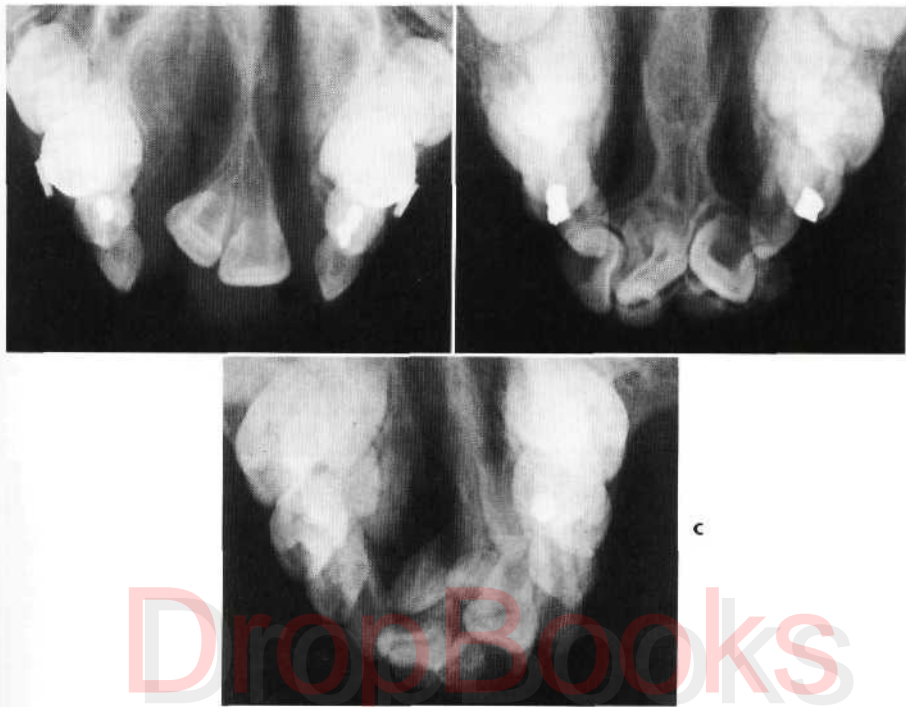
Occlusal radiographs from individuals with various types of cleft deformities. A, Bilateral complete cleft of alveolus and palate. Note absence of permanent lateral incisors. B, Bilateral complete cleft of alveolus and palate. Note absence of permanent lateral incisor on patient's left side. C, Unilateral complete cleft of alveolus and palate. Note supernumerary teeth.
